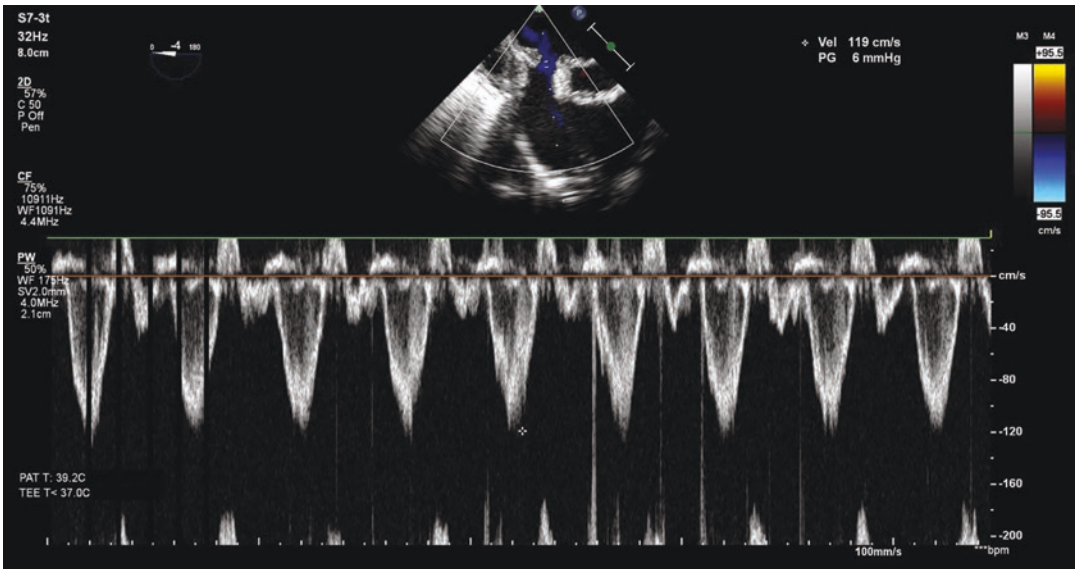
Postoperative TEE, pulse wave Doppler recording in the same view as above (Fig. 14) demonstrating low-velocity flow, and a minimal mean gradient (now shown) in the pulmonary venous baffle pathway
